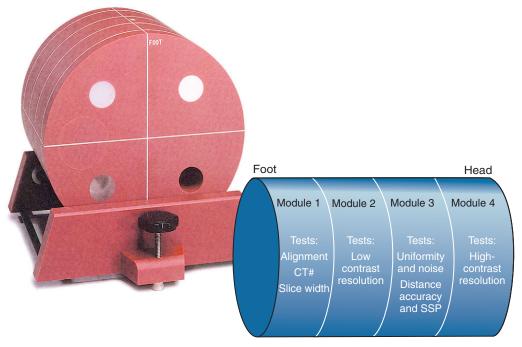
This computed tomography test object is used to evaluate noise spatial resolution, contrast resolution, slice thickness, linearity, and uniformity. (Courtesy Priscilla Butler, American College of Radiology.)
